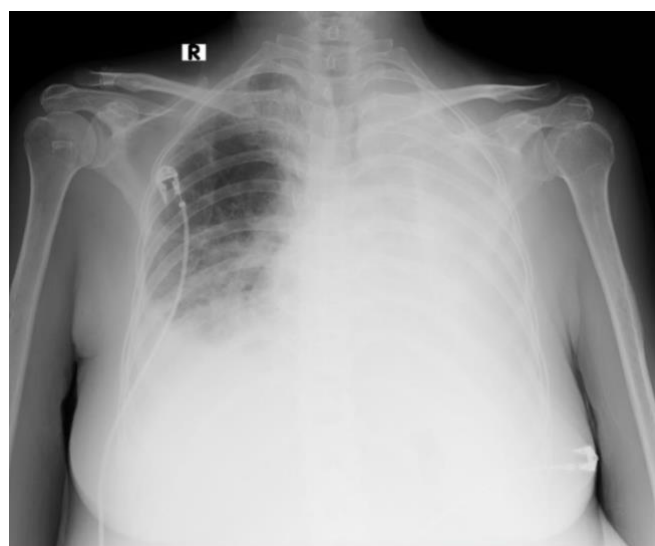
Plain chest radiograph shows infiltrates in the lower middle field of the right lung, right pleural effusion, and left massive pleural effusion
